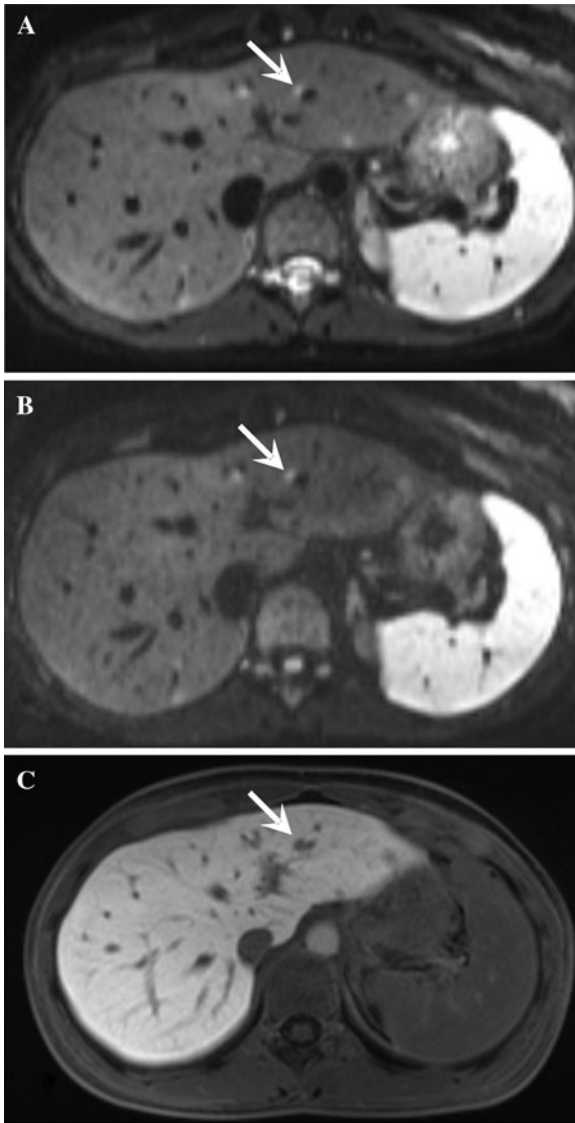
MR images of a 39-year-old woman with breast cancer. Among other small metastases, there is a small lesion in the left liver lobe (*arrow*) that is clearly hyperintense both at $b = 50 \text{ s/mm}^2$ (A) and $b = 600 \text{ s/mm}^2$ (B) and, therefore, suspicious for a metastasis. As the lesion is located in immediate proximity to a vessel, although retrospectively visible, it was not detected by gadoteric acid-enhanced MR imaging (C) by both readers (20 min post injection)
